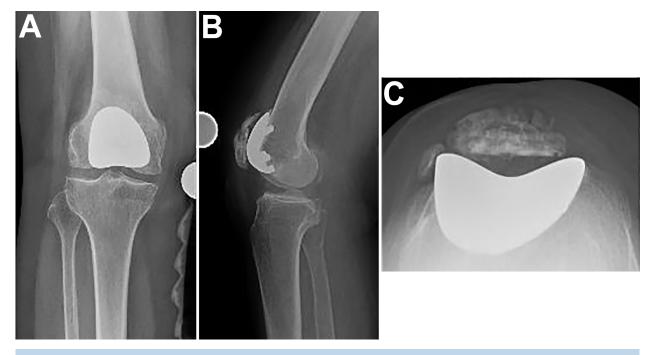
Post-operative radiographs after PFA.
